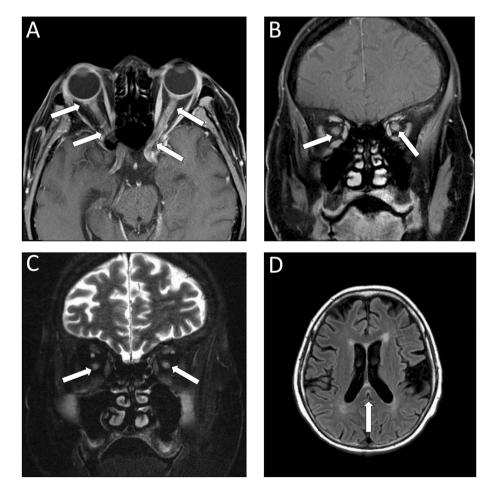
Magnetic resonance imaging (MRI) of the orbits and brain with and without contrast and fat suppression. T1-weighted post contrast axial (A) and coronal (B) cuts show bilateral optic nerve enhancement. T2-weighted coronal (C) cut demonstrates increased signal which can be seen along the whole nerve. T2-weighted FLAIR axial (D) cut demonstrates a curvilinear focus of hyperintensity in the splenium of the corpus callosum consistent with cytotoxicity.
